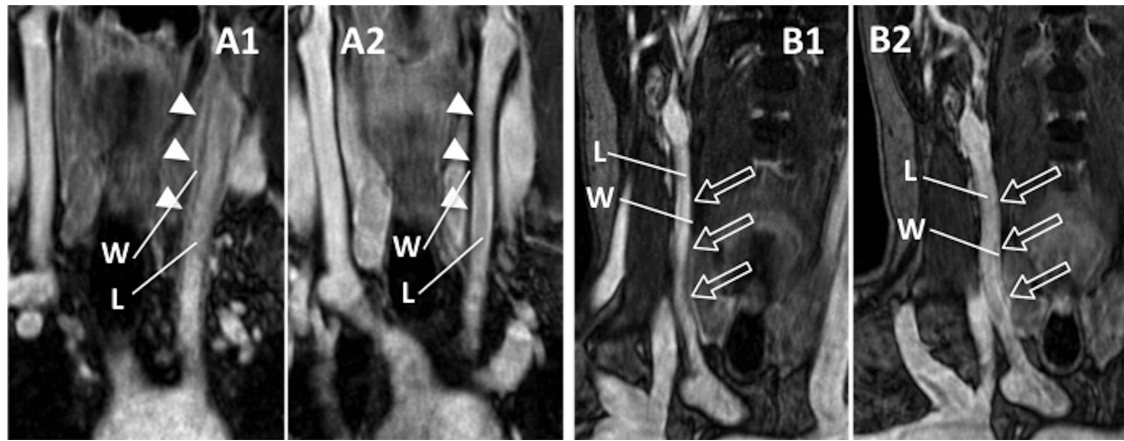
Magnetic resonance imaging followup in 2 patients. Case A: Radiological improvement with thinning (and loss of enhancement) of left carotid arterial wall (arrowheads; A1, October 2008; A2, January 2012). Case B: Radiologic new disease onset in right carotid artery with enhanced vessel wall thickening (arrows; B1, March 2009; B2, February 2011). L: lumen; W: vessel wall.
